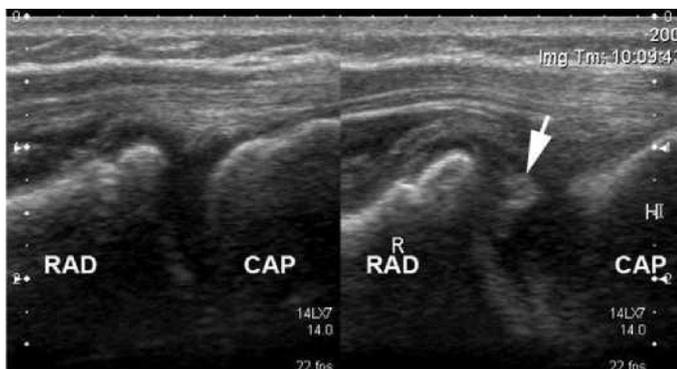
Ultrasound image revealing alteration in the shadow of annular ligament (arrow)
